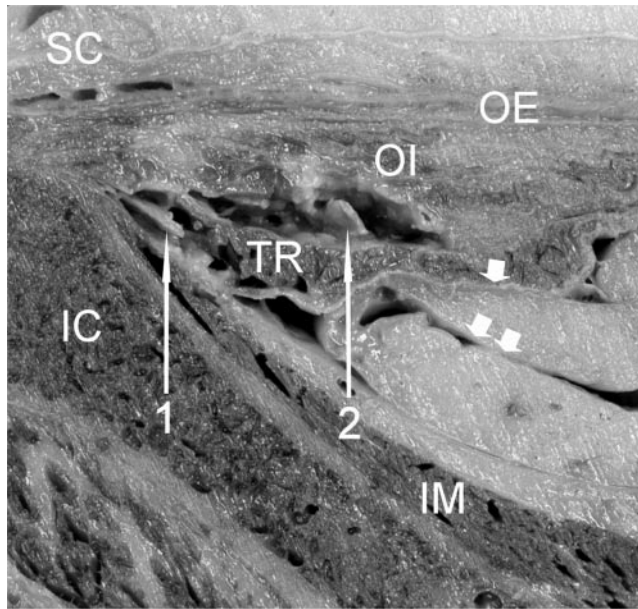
Anatomical cross-section through the region in the plane of the obtained ultrasound image. IC, iliac crest; SC, subcutaneous tissue; OE, external oblique muscle; OI, internal oblique muscle; TR, transversal abdominal muscle; 1, II nerve; 2, IH nerve; IM, iliac muscle; single arrowhead, transversalis fascia; double arrowhead, peritoneum.
